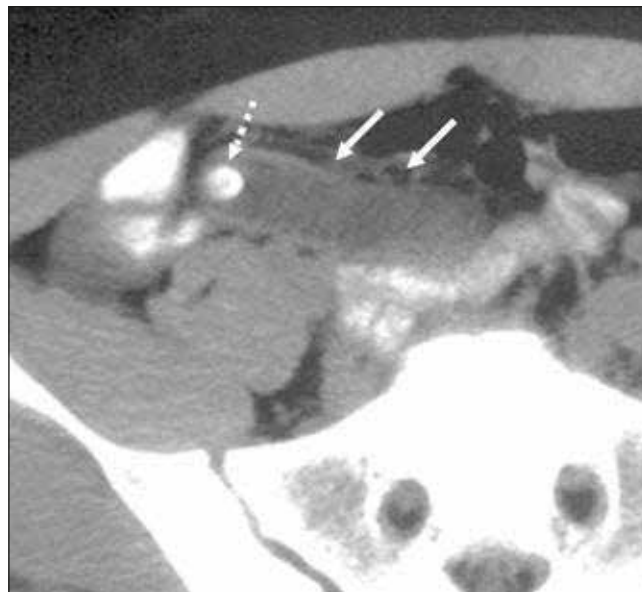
CT scan of acute appendicitis (reproduced with kind permission of Mr Stephen Badger)
